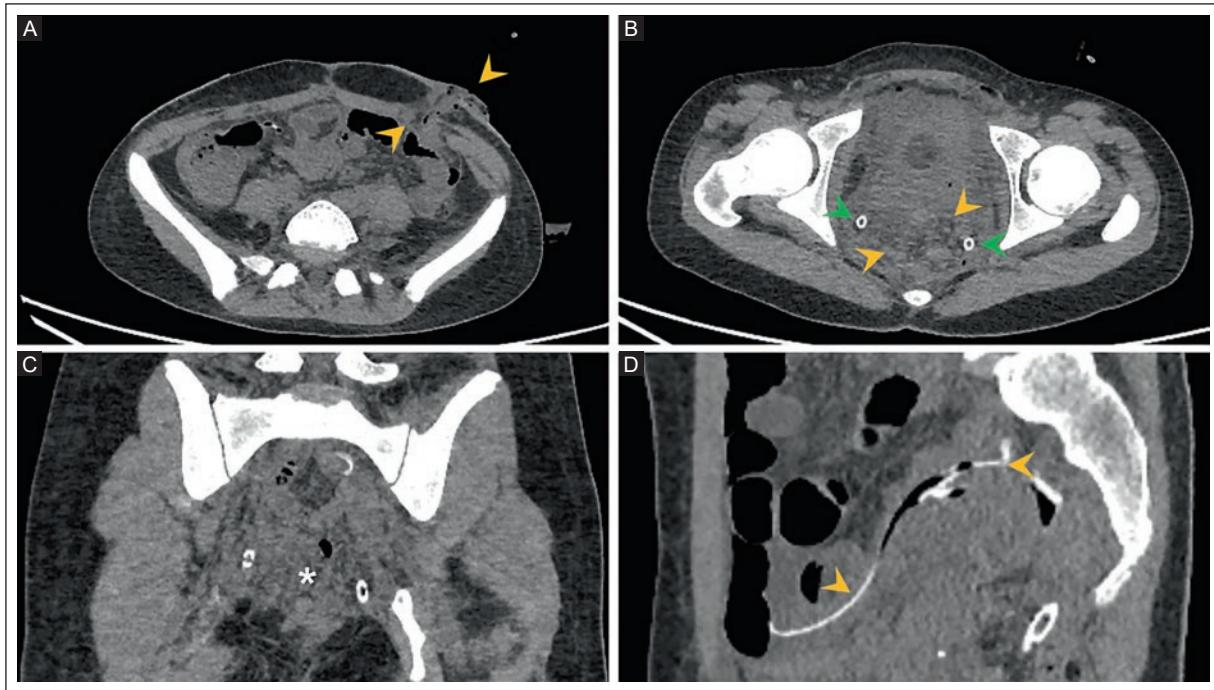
Non-contrast post-surgical abdominopelvic CT. A: axial image of a colostomy stoma (orange arrowheads). B: axial image shows surgical resection of the anorectal segment (orange arrowheads) and silicone drain tubes in the pelvic cavity (green arrowheads). C: coronal image demonstrates persistent serpentine perirectal vessels (asterisk). D: a sagittal image shows a silicone drain tube in the pelvis (orange arrowheads).
